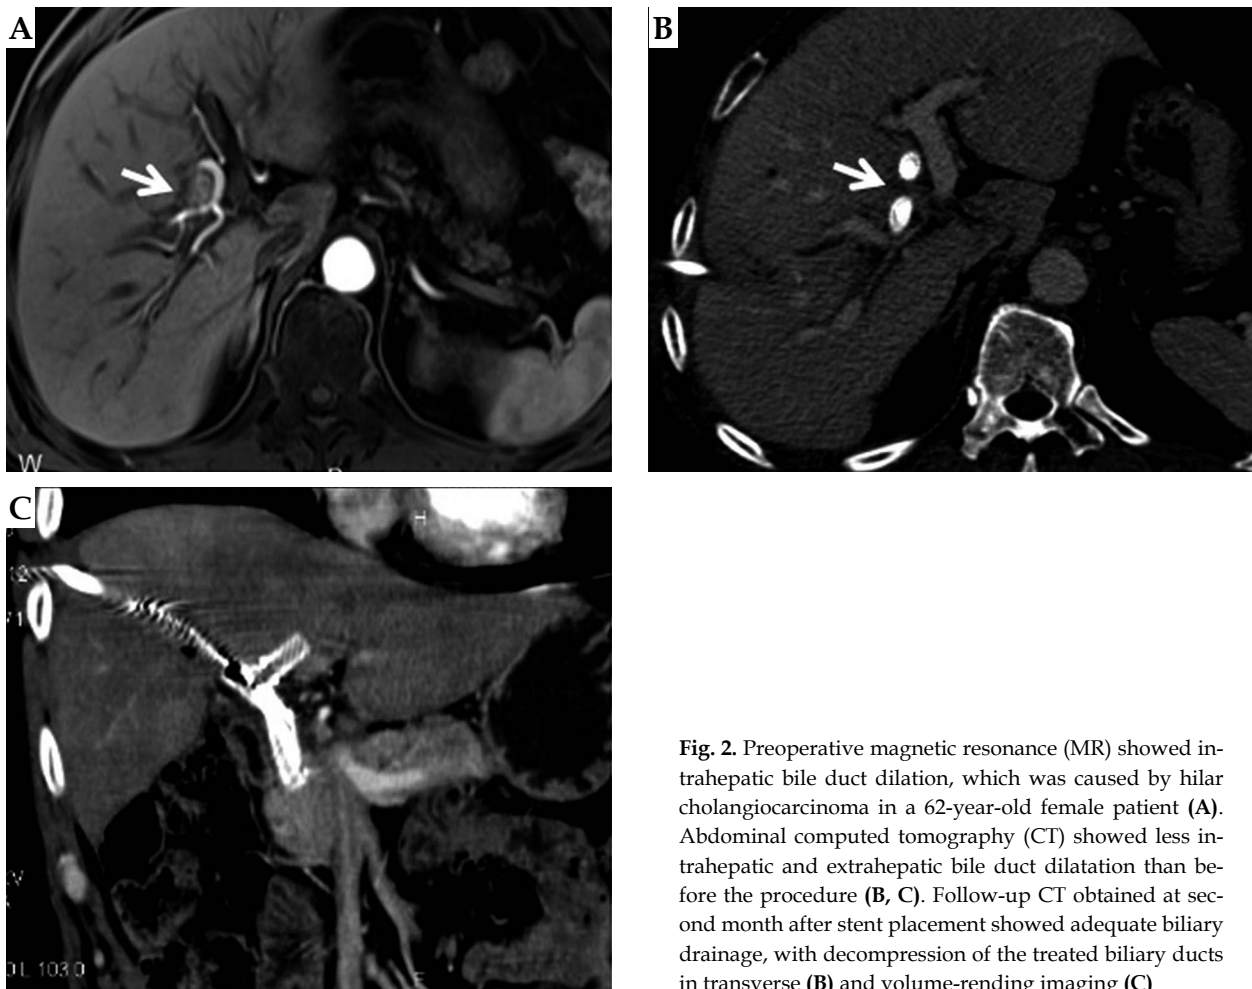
Preoperative magnetic resonance (MR) showed intrahepatic bile duct dilation, which was caused by hilar cholangiocarcinoma in a 62-year-old female patient (A). Abdominal computed tomography (CT) showed less intrahepatic and extrahepatic bile duct dilatation than before the procedure (B, C). Follow-up CT obtained at second month after stent placement showed adequate biliary drainage, with decompression of the treated biliary ducts in transverse (B) and volume-rendering imaging (C)
